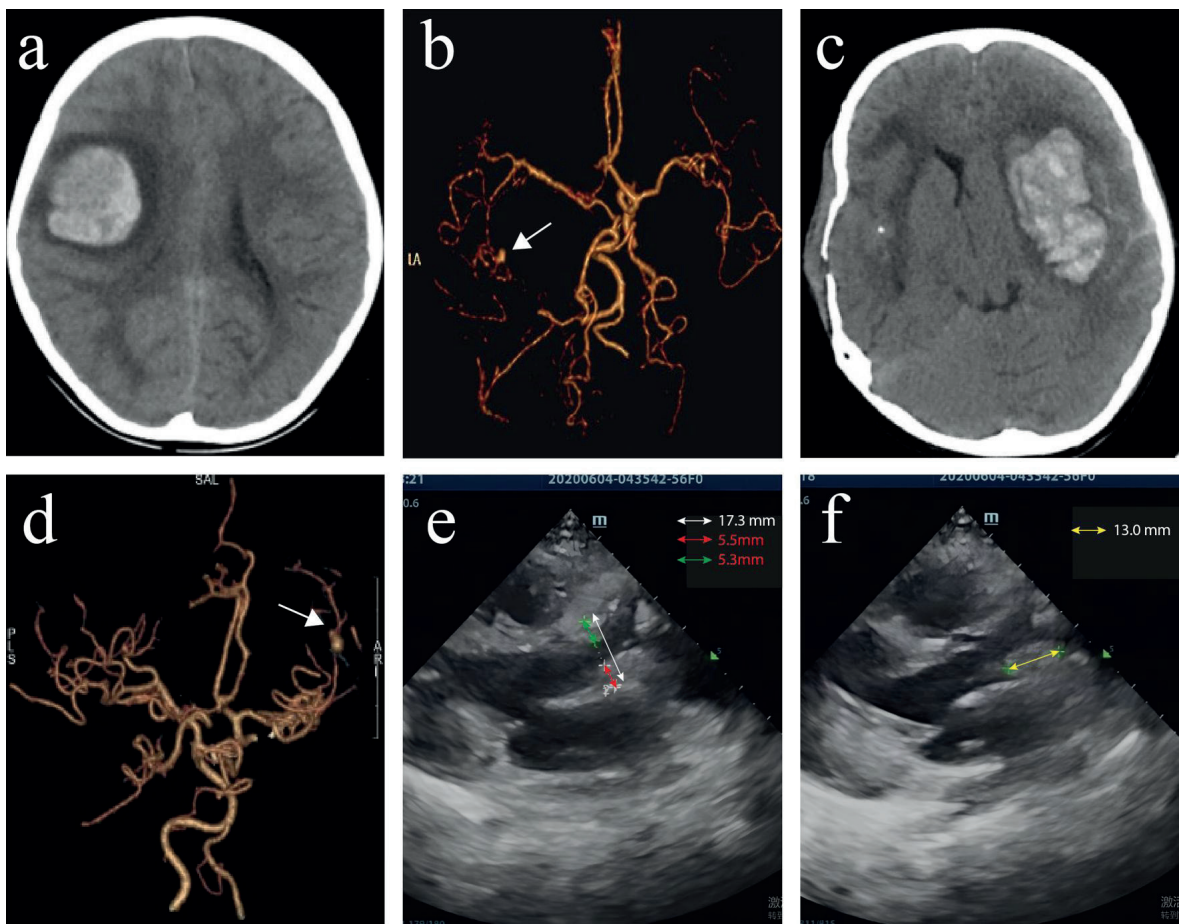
a) Computed tomography (CT) showing the hematoma in the right frontoparietal lobe. b) CT angiography showing a right MCA aneurysm (arrow). c) CT showing the hematoma in the left frontoparietal lobe. d) CTA showing a left MCA aneurysm (arrow). e, f) Echocardiography images demonstrating that the right coronary cusp and non-coronary cusp of the aortic valve are both thickened, with vegetations present on the aortic valve, resulting in significantly restricted valve opening. The white double arrow (e) indicates the anteroposterior diameter of the aortic root (17.3 mm). The red double arrow (e) marks the distance from the non-coronary cusp to the posterior aortic wall (5.5 mm), i.e., the vegetation thickness. The green double arrow (e) indicates the distance from the right coronary cusp to the anterior aortic wall (5.3 mm). The yellow double arrow (f) indicates the vegetation length (13.0 mm). The aortic valve opening diameter is 6.5 mm (calculated as 17.3 mm - 5.5 mm - 5.3 mm).
